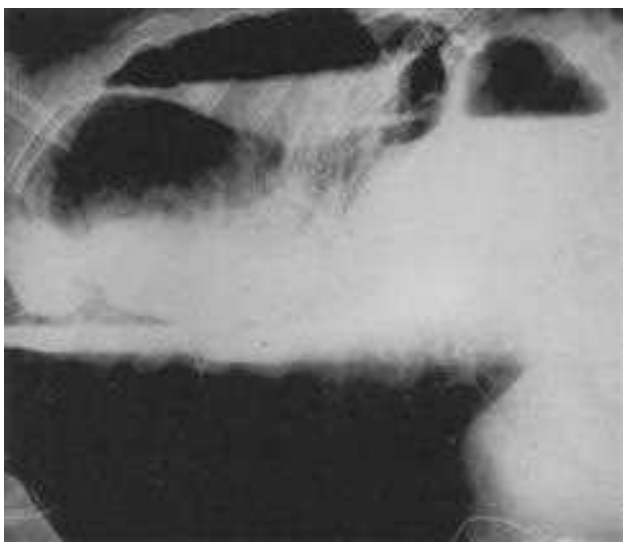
Radiographic study of a patient with a perforation of the esophagus using water-soluble contrast material. The patient is placed in the lateral decubitus position with the left side up to allow complete filling of the esophagus and demonstration of the defect.
